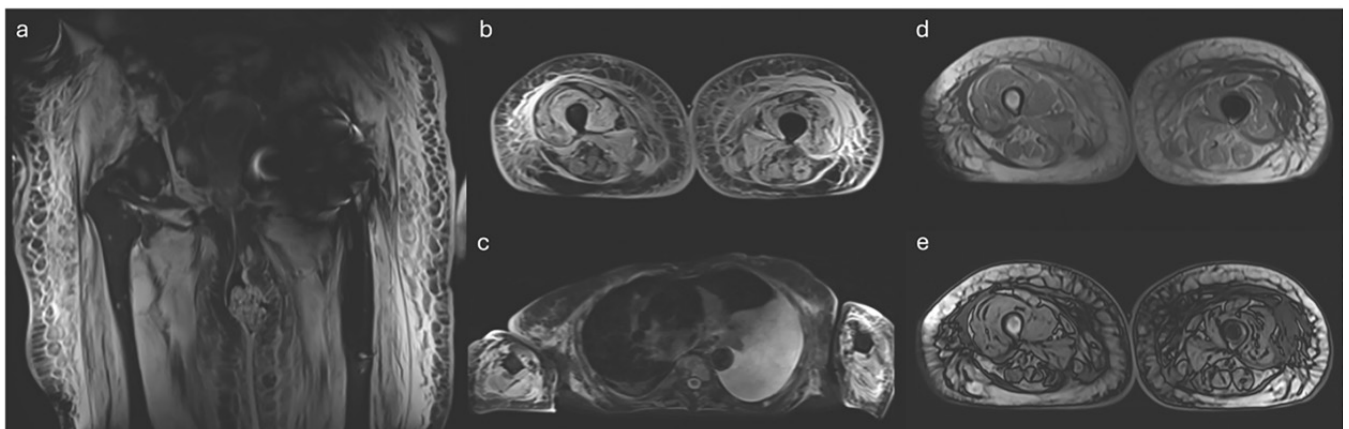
Muscular MRI showing diffuse muscular oedema of thighs and arms, in particular diffuse muscular bellies hyperintensity is depicted on coronal (A) and axial (B) STIR at the level of the thighs and on axial STIR (C) at the level of the arms. On these images, also fluid epimysial collection and diffuse subcutaneous fat oedema are displayed, especially at thighs' level. On the right, axial dual-echo images at the level of the thighs show minimal intramuscular signal drop from in-phase (D) to out-of-phase (E) images representing minimal fat infiltration in all thighs' muscles.
